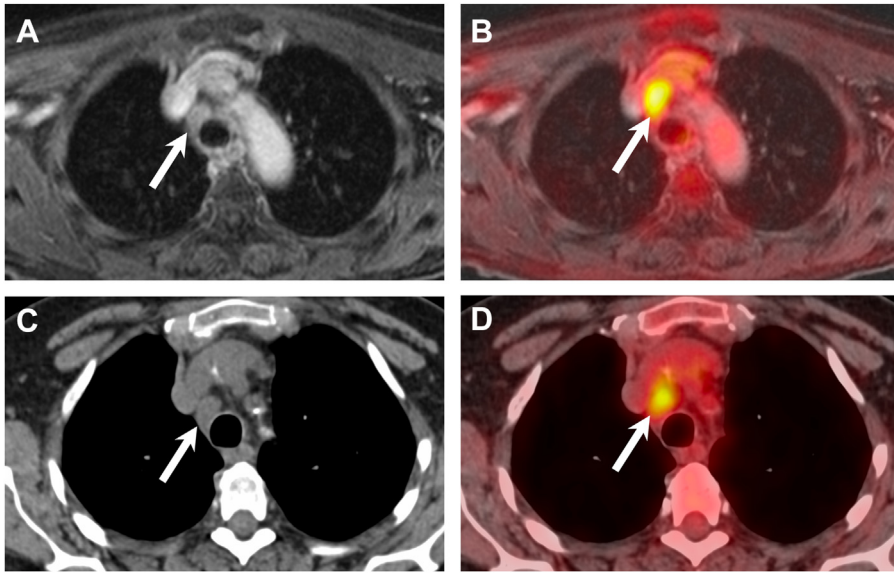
False-positive PET/MR imaging (A,B) and PET/CT (C,D) in a 63-year old woman imaged for follow-up of an SCC of the larynx (T3N1) treated with radiochemotherapy. Both PET/MR imaging and PET/CT were rated as positive for distant mediastinal lymph node metastases. An enlarged mediastinal lymph node (arrows) shows a combination of high focal FDG uptake (SUVmax on PET/MR imaging = 7.5 and SUVmax on PET/CT = 6.7) and slightly heterogeneous contrast enhancement on the contrast-enhanced fat-saturated MR image. On the corresponding CT image, due to the absence of contrast enhancement, only lymph node enlargement was present (13 × 15 × 17 mm). The lymph node was rated with a score of 5 (highly suspicious) on PET/MR imaging and a score of 4 (moderately suspicious) on PET/CT. However, mediastinoscopy with biopsy-revealed sarcoidosis. (Reproduced from Katirtzidou et al.²⁴)
